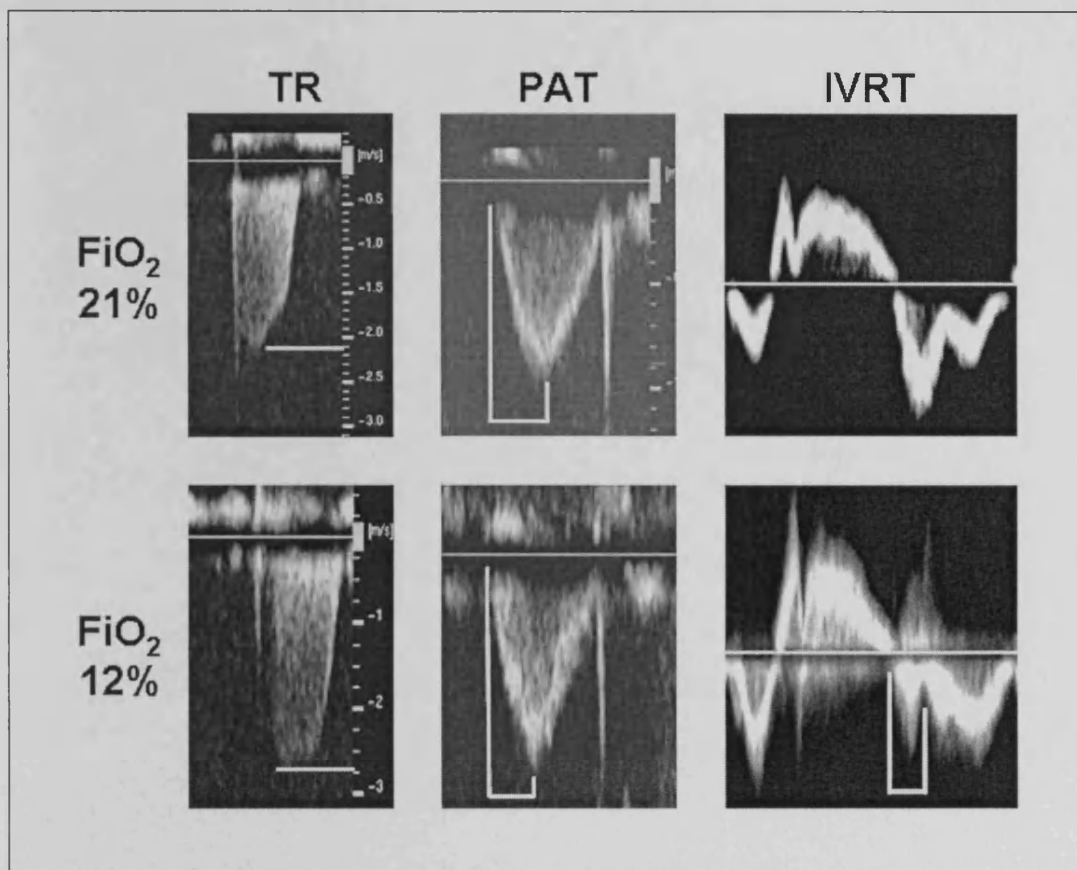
Example, annotated, echocardiographic images recorded to measure the three surrogate markers of PAP, acquired at “baseline” (top row) or “pre-infusion” (bottom row).
